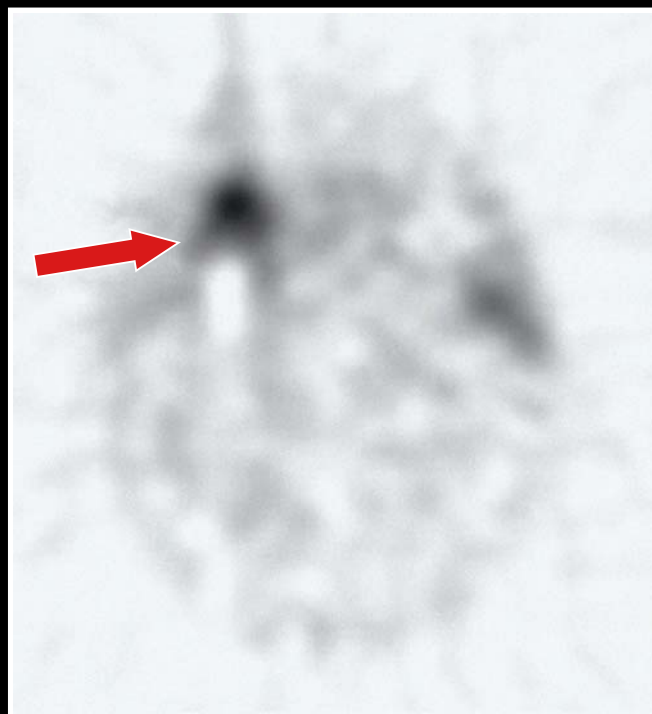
Parathyroid scintigraphy with [^{99m}Tc -MIBI] showing hypercaptating latero-cervical mass on the right (arrow), suggestive of a parathyroid adenoma measured at approximately 2.6 cm.
